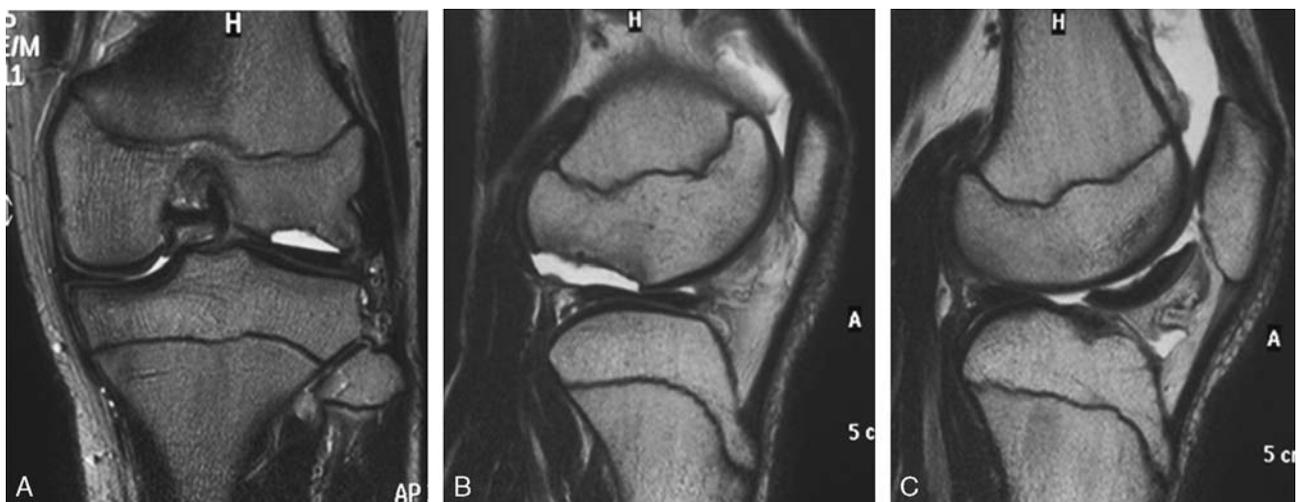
T2-weighted magnetic resonance imaging of left knee joint reveals large bone defect in the lateral femoral condyle and loose body in the intercondylar area (A: coronal view, B and C: sagittal view).
